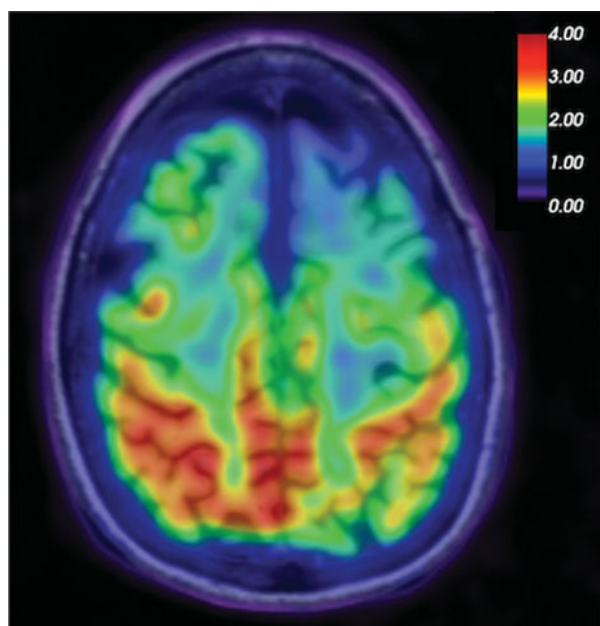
[^{18}F]AV-1451 PET co-registered with MRI in a case of corticobasal syndrome with underlying Alzheimer's disease pathology; color bar displays legend for [^{18}F]AV-1451 SUVR (standard uptake value ratios) values.
